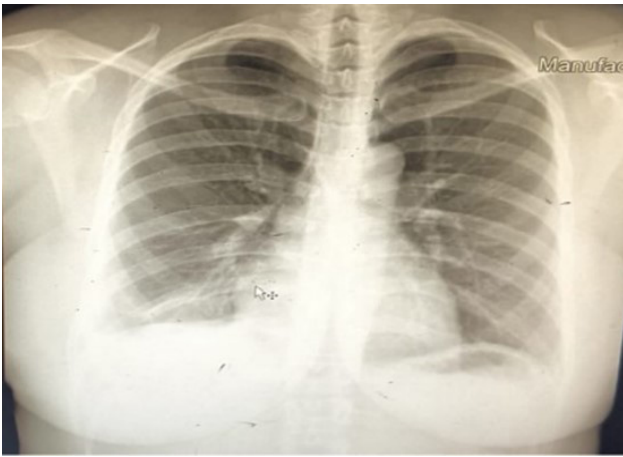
Follow-up chest X-ray (one-year post surgery) revealed resolution of the pleural effusion.
